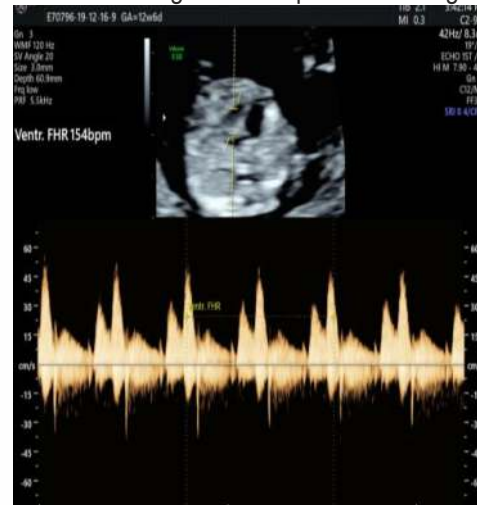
Tricuspid Flow Doppler
